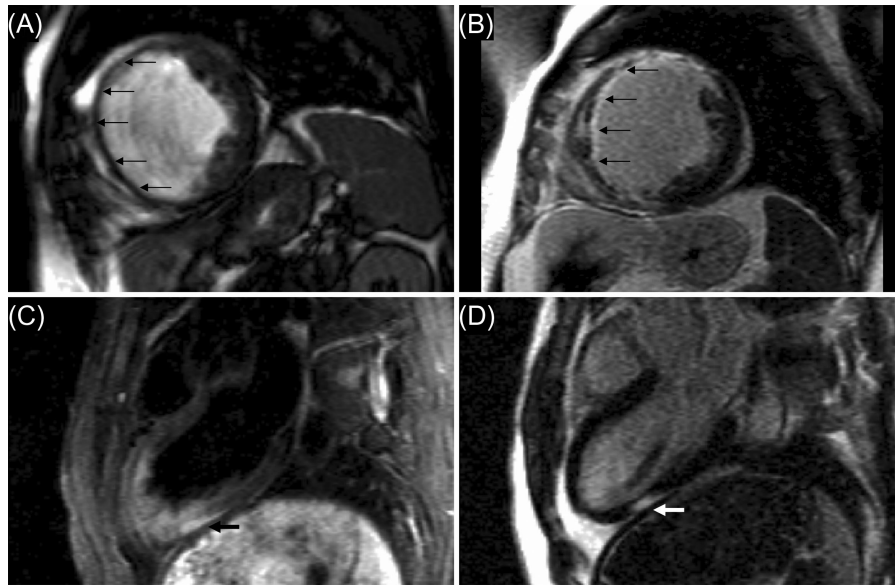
Late gadolinium enhancement-cardiovascular magnetic resonance appearances of myocardial infarction and myocarditis. (A) A cine sequence of mid-ventricular short-axis slice in a patient with classic features of myocardial infarction with anterior, inferior, and septal wall thinning (arrows). (B) The corresponding gadolinium-enhanced image demonstrating near-transmural late enhancement of the thinned region described (arrows). (C) A T2-weighted view of the left ventricular outflow tract, a focal area of increased signal in the inferolateral left ventricular wall indicating inflammation (arrows). A corresponding gadolinium-enhanced image (D) shows patchy, predominantly epicardial late enhancement indicating fibrosis (arrows). This pattern is typical of acute myocarditis.
